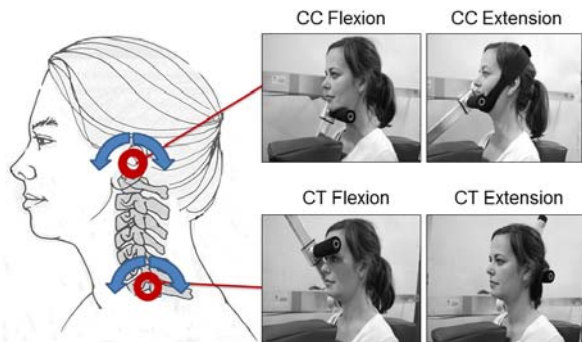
Dynamometry configuration demonstrating the axes of measurement permitting recording of craniocervical (CC) and cervicothoracic (CT) flexion and extension performance [1].
